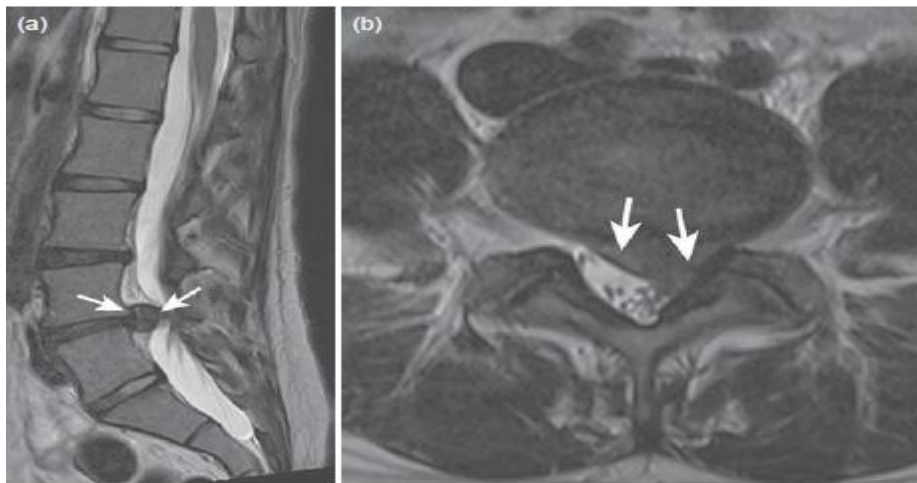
MRI in acute lumbar radiculopathy. (a) Sagittal and (b) axial T2-weighted images show a very large left L4–L5 disk extrusion compressing the thecal sac [10].
